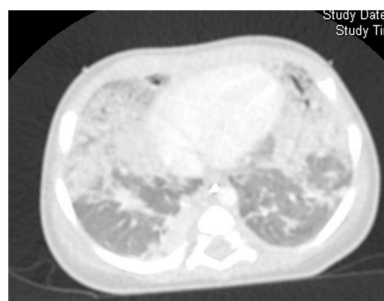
CT with bilateral granular opacities and ground-glass opacification.
